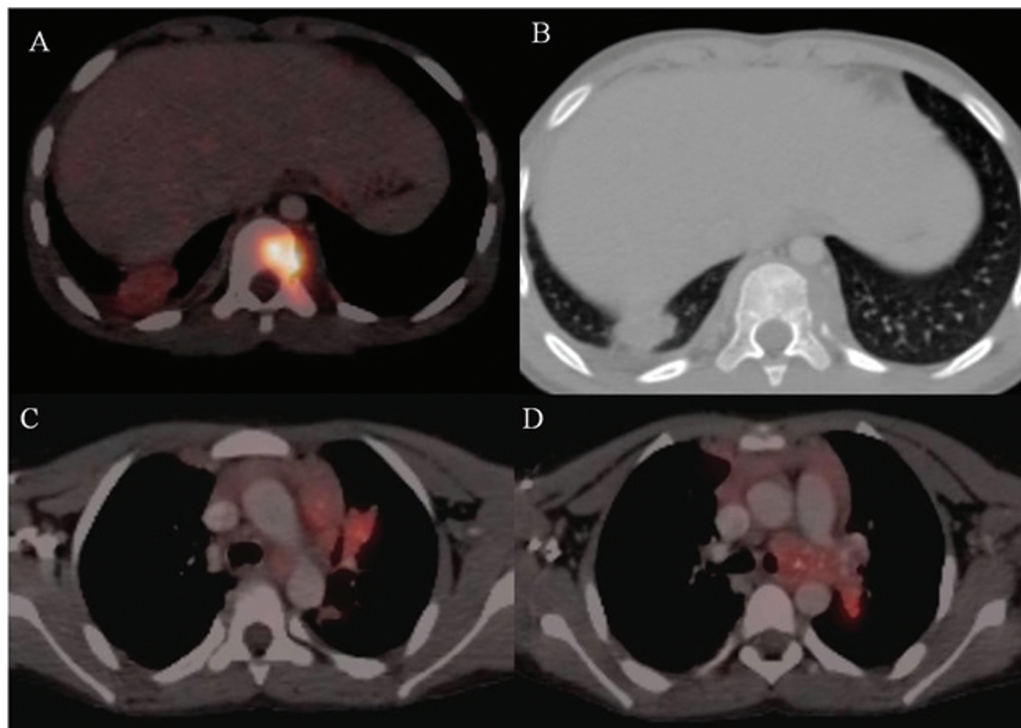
(A, B) Axial positron emission tomography-computed tomography (PET-CT) shows a lytic lesion with associated soft tissue involving body of D10 vertebrae. (C, D) Axial PET-CT shows pleura and parenchymal nodules with associated mediastinal lymph nodes with foci of calcification within.
